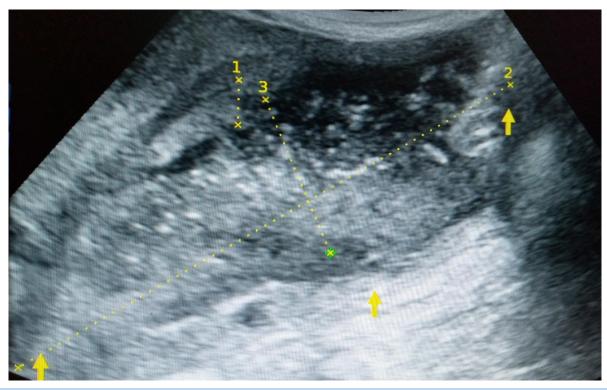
Abdominal ultrasonogram showing distended gall bladder with surrounding peripheral hypoechoic halo of acute cholecystitis; the gallbladder measures about 130mm x 60mm in length and width. Wall thickness is about 17mm.
